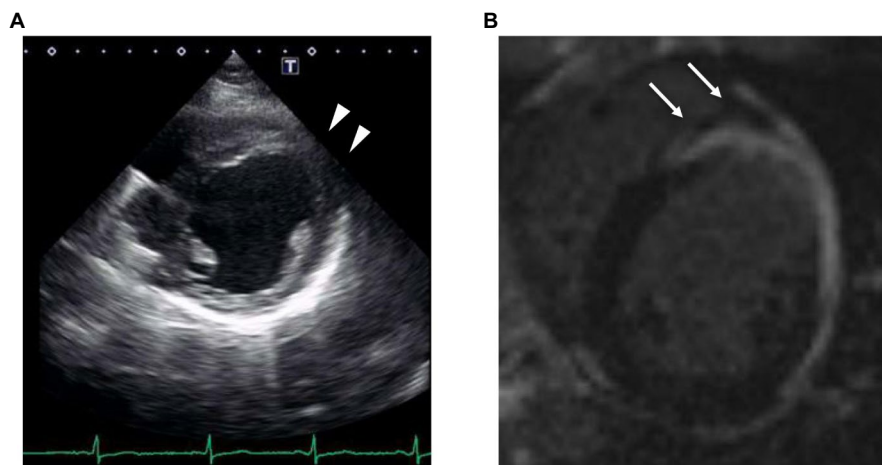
Focal aneurysm (arrow head) at the anterior left ventricle on echocardiography (A). Transmurial extension of delayed gadolinium enhancement (arrows) on cardiac magnetic resonance imaging (B).
